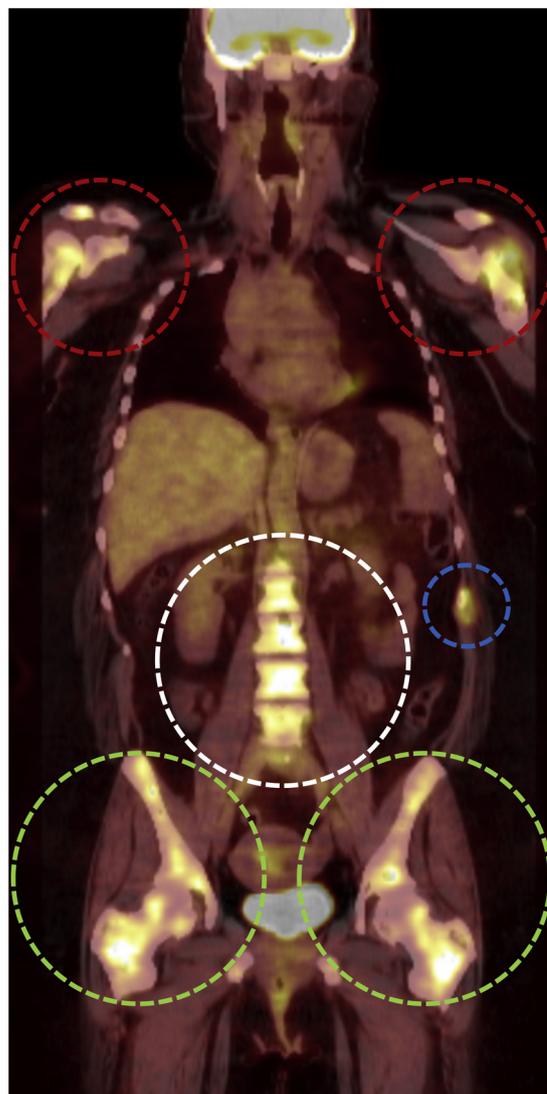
Fluorodeoxyglucose positron emission tomography-computed tomogram scan that shows multiple bony metastases from basal cell carcinoma of the whole axial skeleton, including the right and the left humerus (red circles) with a pathological fracture of the left humerus, the spinal column (white circle), the ribs, (blue circle) the right and left pelvis, and the femoral head (green circles).
